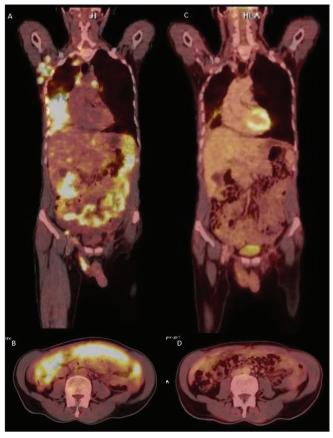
Pre erlotinibcoronal (A) and axial (B) fused PET/CT, and showing soft tissue thickening in peritoneal metastasis. Post erlotinib coronal (C) and axial (D) fused PET/CT showing response to treatment.
